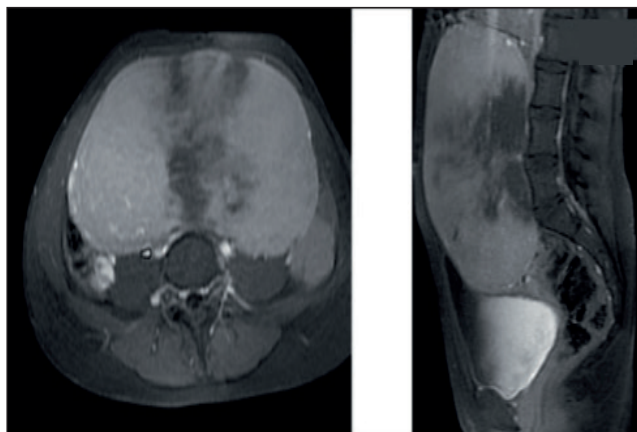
The MRI view of the mass.
